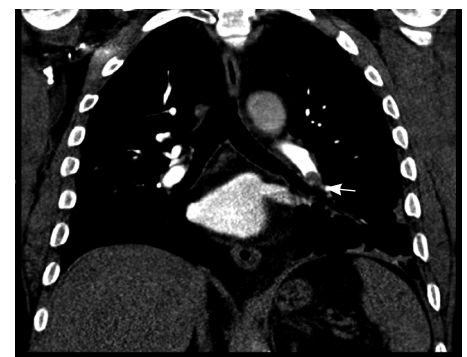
Computed tomography pulmonary angiogram showing left lower lobe pulmonary embolism (arrow) within the segmental and sub-segmental pulmonary arteries, plus some consolidation within the left lower lobe.
